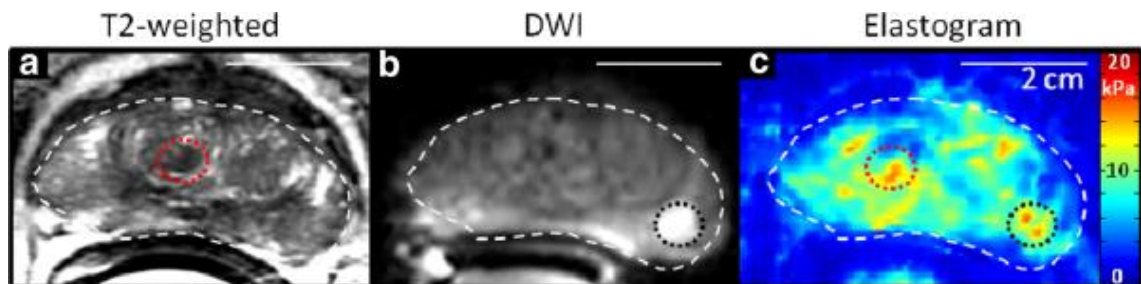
A patient was diagnosed with PCa before imaging. (a) T2-weighted image, (b) diffusion-weighted image, (c) MR elastogram. Two ROIs with abnormal signals were selected in a prostate outlined with a white dashed line. Adapted from Arani et al. 2013 [81].
